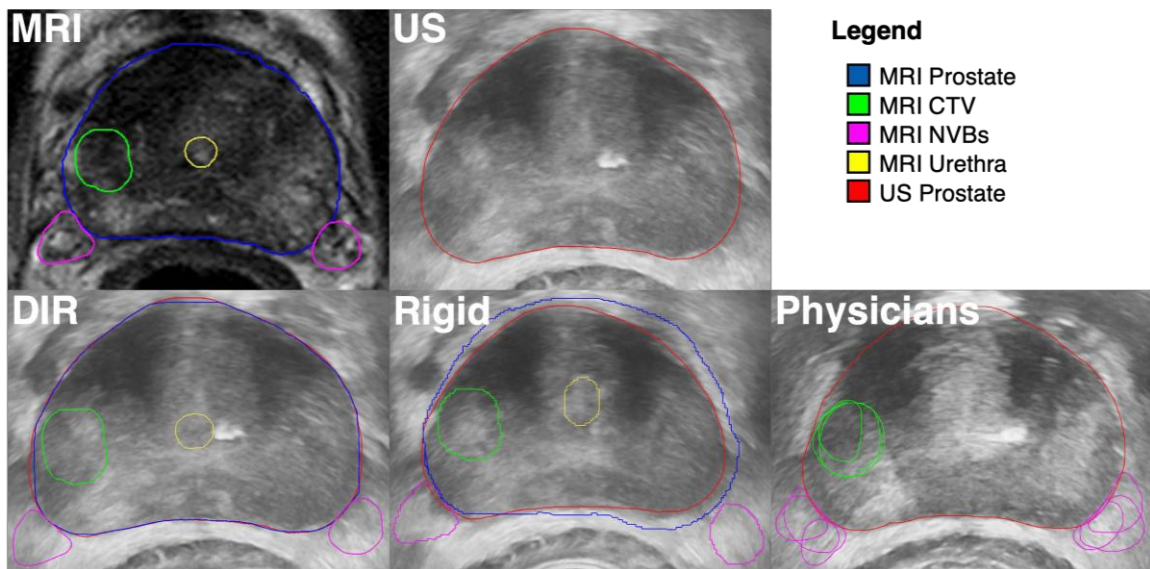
Example clinical registration results for one retrospective HDR-BT case. The top row shows the physician-contoured MRI and US as well as the contour legend. The bottom row shows the MR-to-US registration using our DIR algorithm, manual rigid registration, and cognitive fusion completed by three physicians, respectively.
